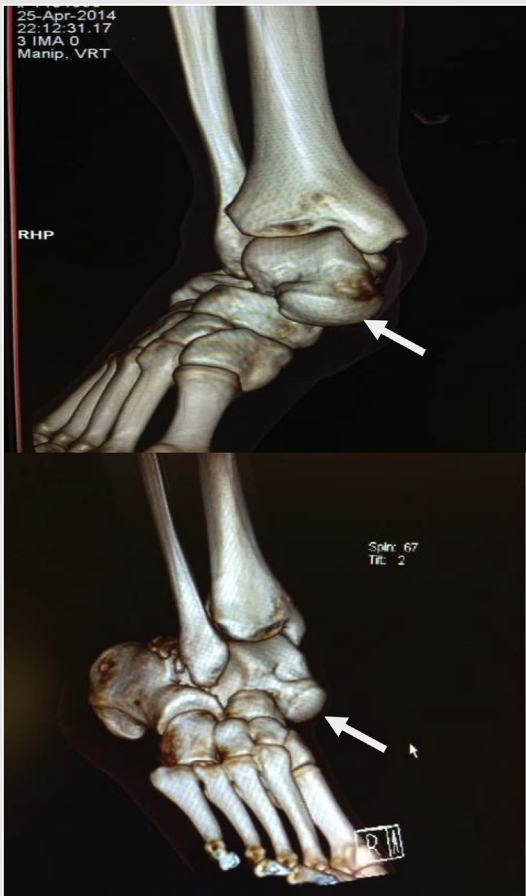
Pre-reduction CT scans (white arrow: talus head).
